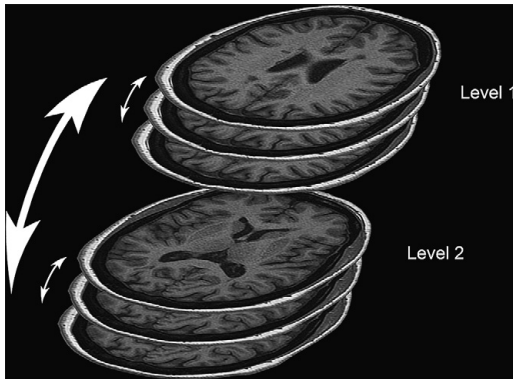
Two anatomical levels analyzed from all image series. Three sequential images from T1-weighted series from both levels were analyzed.
